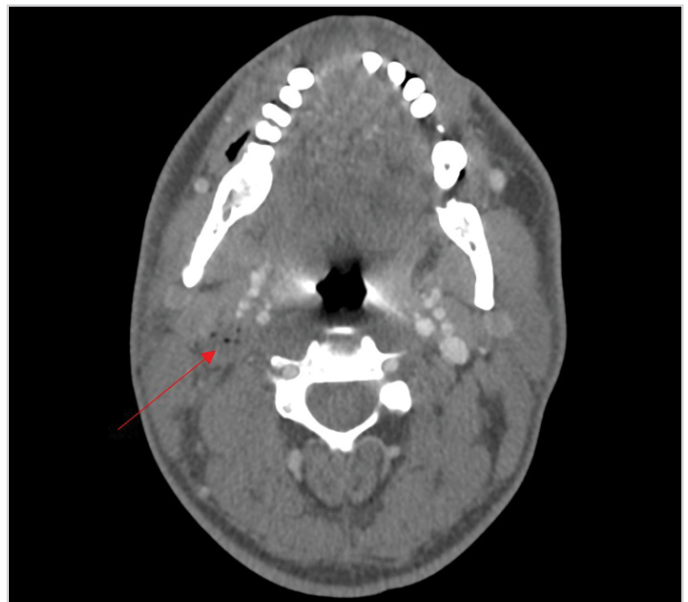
The red arrow shows air densities with thrombosed appearance in the right internal jugular vein in the contrast-enhanced CT angiography of the neck.
